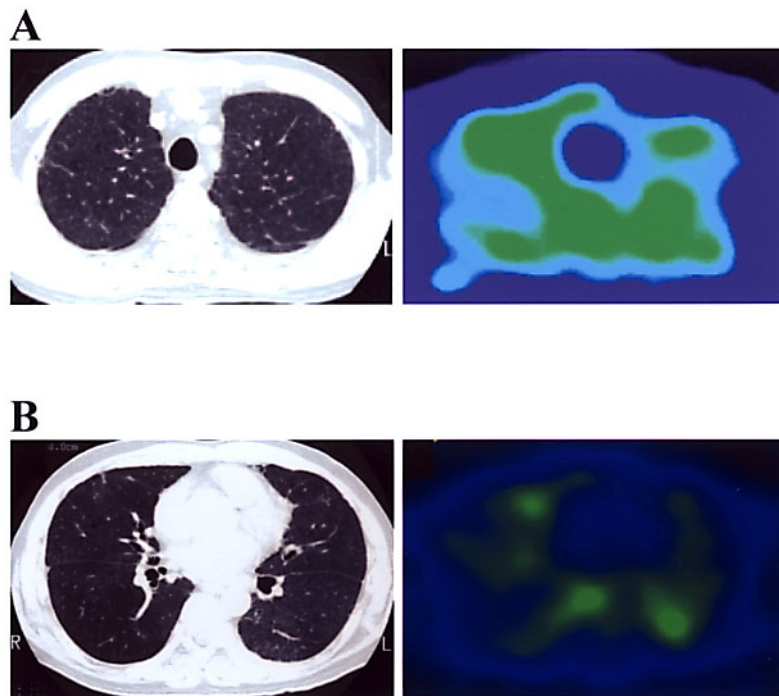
HRCT scan (*left panels*) and ^{67}Ga -SPECT (*right panels*) in both upper (A) and lower (B) lung fields 1-month after whole-lung lavage. HRCT shows almost complete disappearance of ground-glass opacities whereas mild ^{67}Ga uptake is persisted.
